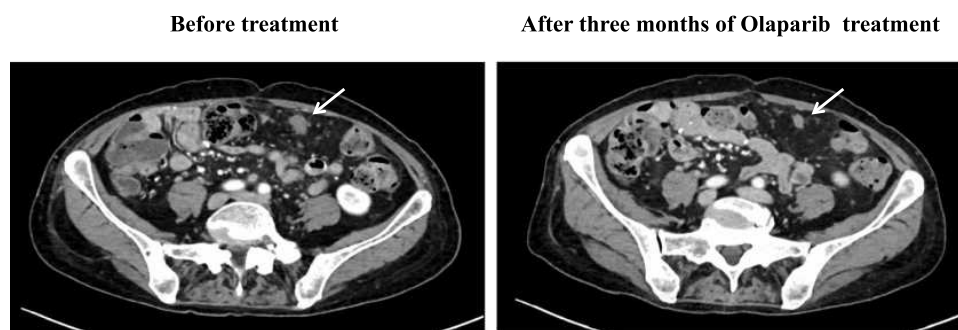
CT images of peritoneal metastasis before and after Olaparib treatment (white arrows: peritoneal metastases).
